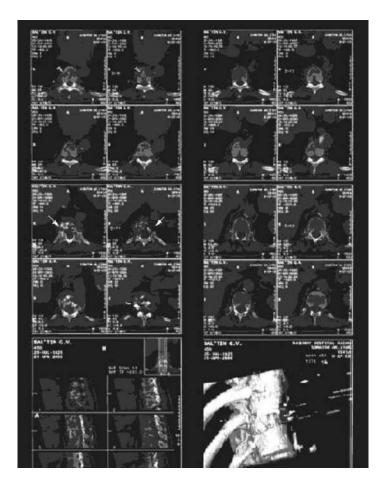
Magnetic resonance images (MRIs) of patient with backbone metastases (before treatment with bacteria). Compression fracture of the Th.XI vertebral body with wedge-shaped deformity and slight consequent kyphosis are detected. There are sclerotic bony fragments, but the presence of lytic process is also evident; this is most conspicuous in the vertebral arches. Surrounding soft tissues are somewhat widened. There is another lytic area (approximately 1.5×2.3 cm) on the left anterior aspect of the Th.X vertebral body adjacent to Th.X intervertebral space, affecting the cortical bone as well. A third lytic area is demonstrated in Th.IX vertebral body on the right side with a size of approximately 1×2.5 cm. It has lobulated contours with sclerotic margins. There are moderate sclerotic degenerative appositions at the Th.XI facet joints. There is no significant spinal canal stenosis at this point. Lytic areas in Th.XI vertebra involving the arches: white arrows; lytic lesion in Th.IX vertebral body with sclerotic margin: short arrow; lesion in Th.X vertebral body at its lower rim. (Adapted from Maklov et al., 2006a. With permission).
